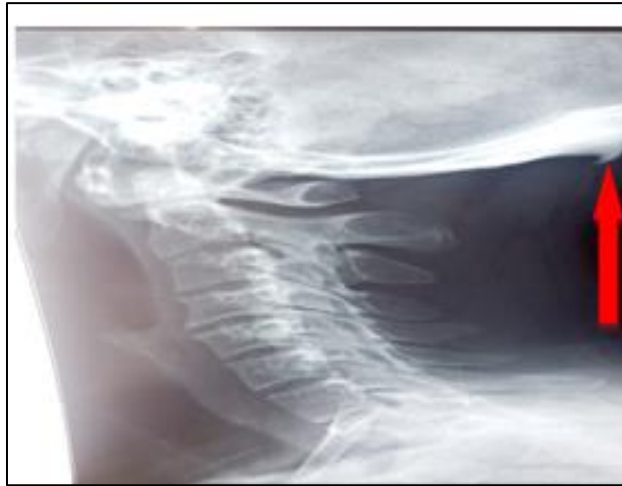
Lateral cervical spine radiograph showing an enthesophyte at the external occipital protuberance
